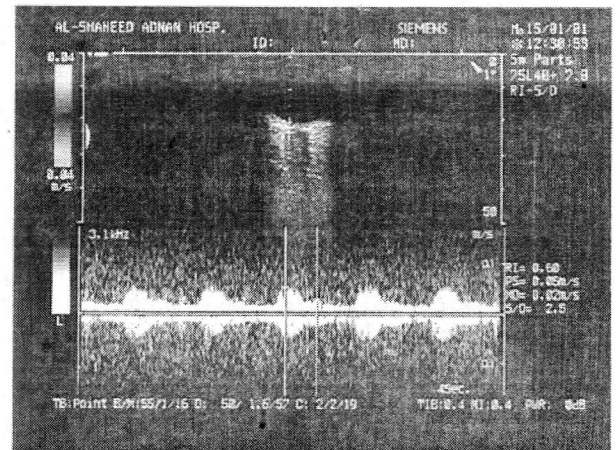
Posterior ciliary artery (Abnormal pulsated Doppler waveform)
